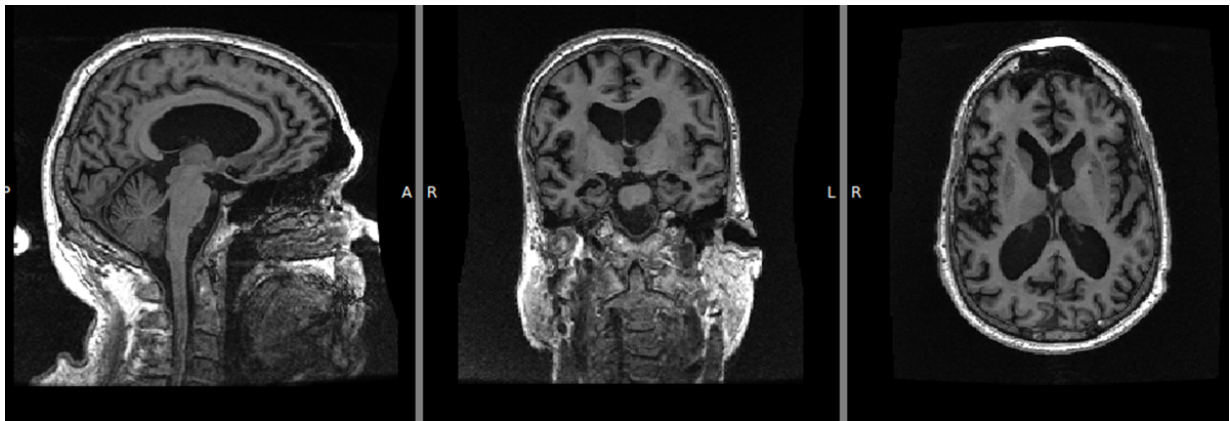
Example of an MRI scan of an AD subject of the ADNI data set: subjectID: 003S4136
